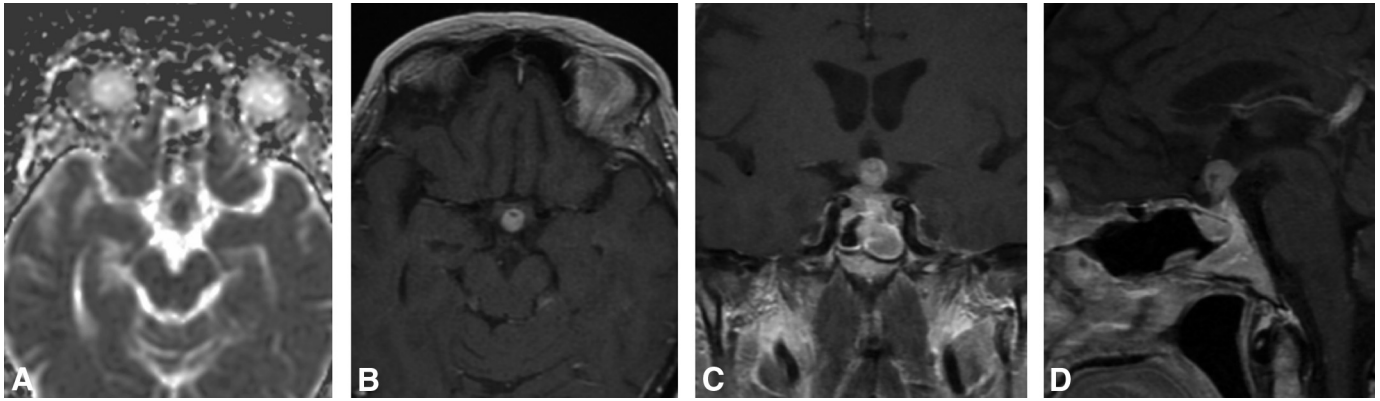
Hemangiopericytoma. Axial ADC (A), and axial (B), coronal (C), and sagittal (D) postgadolinium T1WI of a hemangiopericytoma. A 74-year-old woman with a history of bitemporal hemianopia. MR imaging demonstrates an intrasellar hemangiopericytoma, with compression of the optic chiasm and extension into the sphenoid sinus and cavernous sinus.
